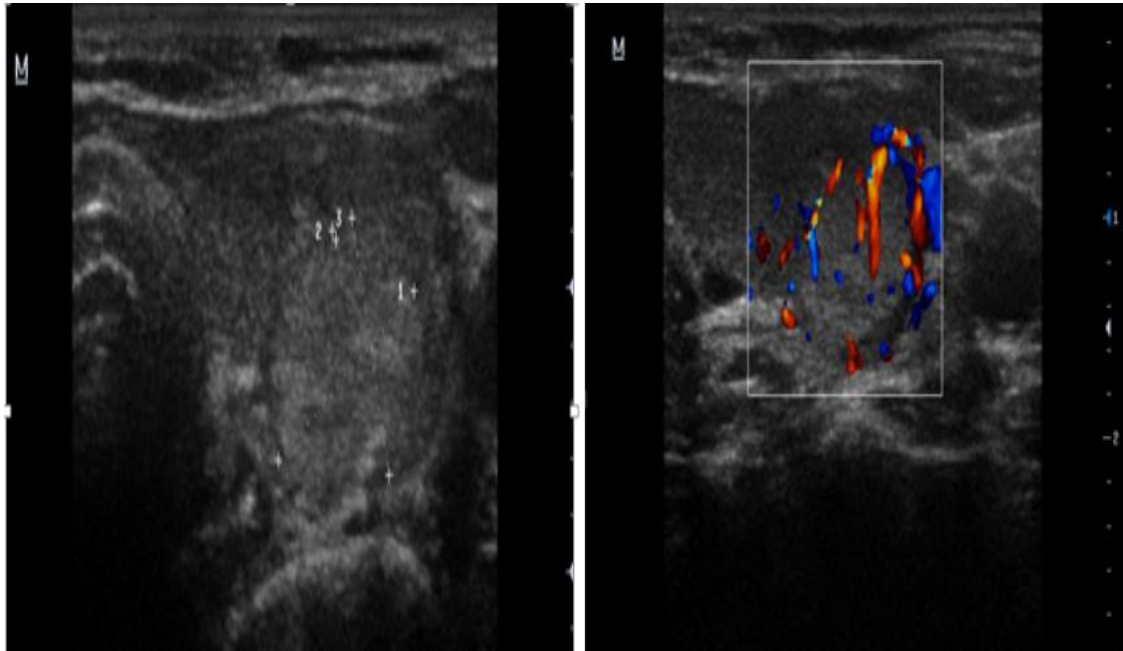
(a) Gray scale & (b) Colour Doppler USG images showing hyperechoic nodule with irregular margins, showing perinodal as well as intranodal vascularity on Doppler . USG diagnosis of Malignant nodule was made. FNAC diagnosis was of hyperplastic nodule. (False Positive)
